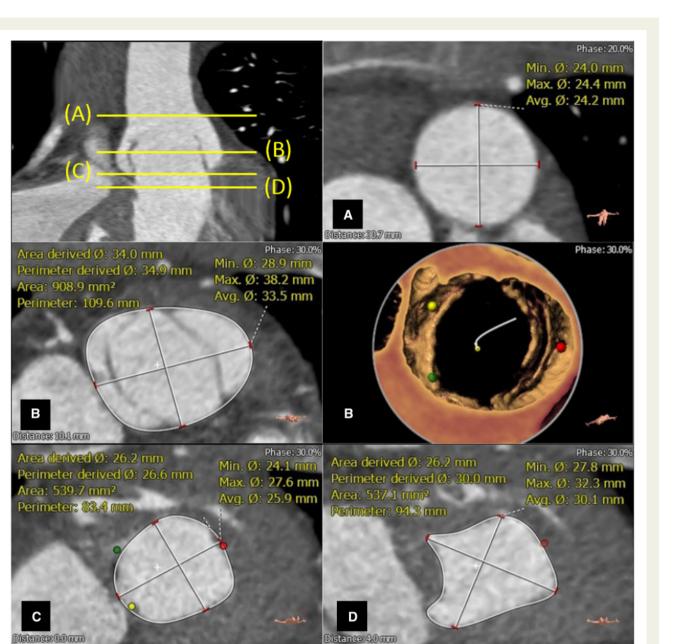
Multidetector computed tomography aortic valve complex analysis. (A) Sinotubular junction. (B) Sinuses of Valsalva. (C) Aortic annulus. (D) Systemic right ventricular outflow tract.
